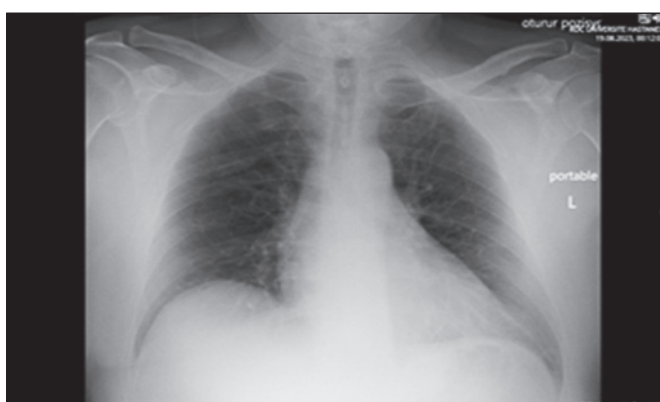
Chest-X-ray after procedure showing no catheter fragment.
